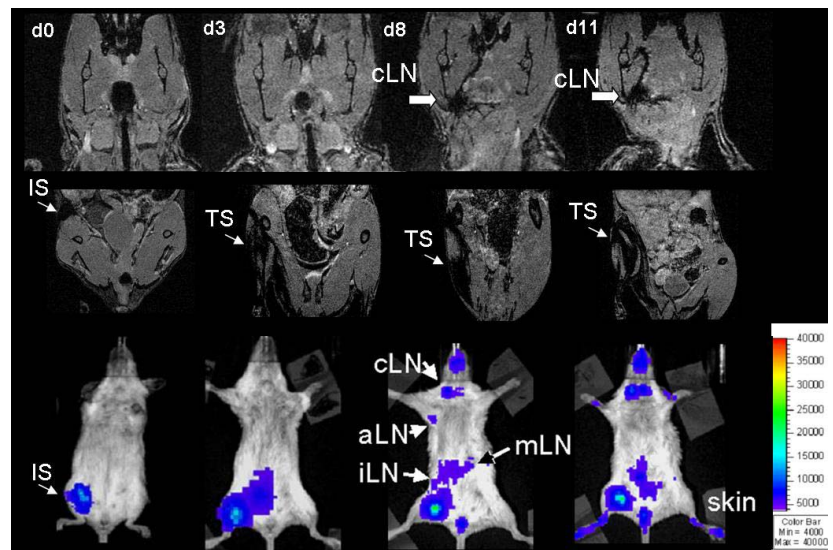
In vivo Imaging to track the labelled DCs after injection. Upper Row MRI of the cervical region, showing signal voids in the region of the cLN as indicated on d8+d11. Middle row: Signal void at the injection site (d0) and in the surrounding tissue (d3, 8, 11) as expected from the corresponding BLI. Lower row: Local injection of luc⁺ SPIO⁺ CD11c⁺ cells in the right proximal leg on the day of BMT (C57B/6 → Balb/c). Trafficking is monitored with BLI on the indicated days with: injection site= IS, cLN = cervical lymph node, aLN = axillary lymph node, iLN = inguinal lymph node, mLN = mesenteric lymph node, TS = Tissue.
